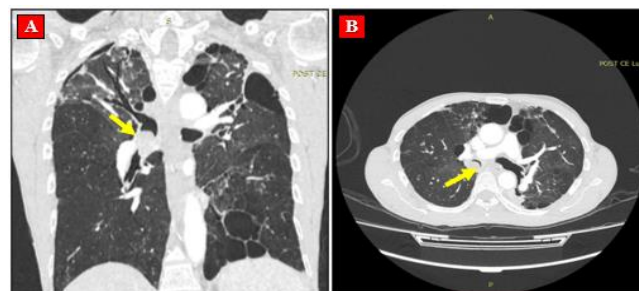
Computed tomography of the chest revealing a right endobronchial mass (1.3 × 1.9 cm)
